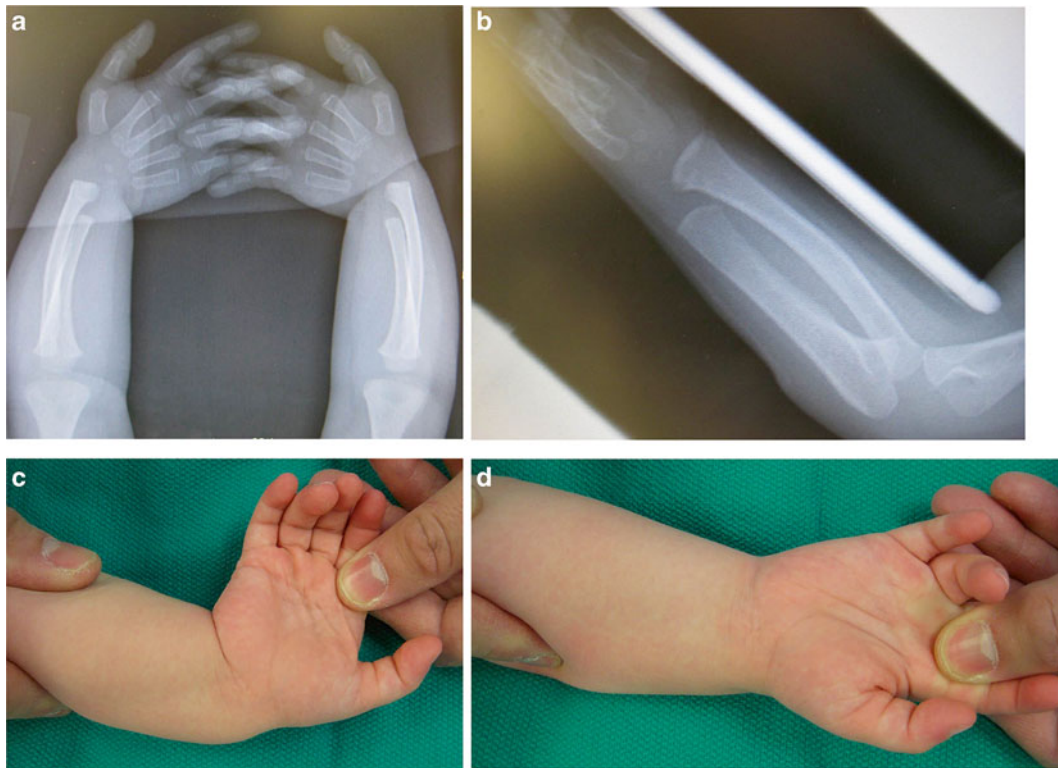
(a) Anteroposterior and (b) lateral radiographs of a 2-year-old boy with bilateral ulnar longitudinal deficiency type II/A. (c) Clinical photograph showing excessive wrist ulnar deviation. (d) The wrist position rests in neutral
